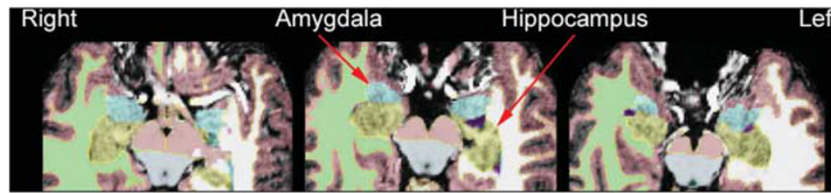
Volumetric differences in mesial temporal structures. Both right amygdalar and left hippocampal volumes were significantly decreased in pathological gambling (PG) subjects ($n = 32$) compared with healthy comparison (HC) subjects ($n = 47$). High-resolution T1-weighted anatomical images were acquired using a 3-T scanner (Trio; Siemens) and mesial temporal structures outlined using FreeSurfer software (<http://www.surfer.nmr.mgh.harvard.edu>).
